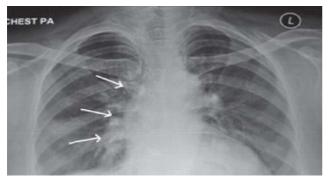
Chest radiograph (postero-anterior view [PA]) showing resolution of para-mediastinal effusion (white arrows).
